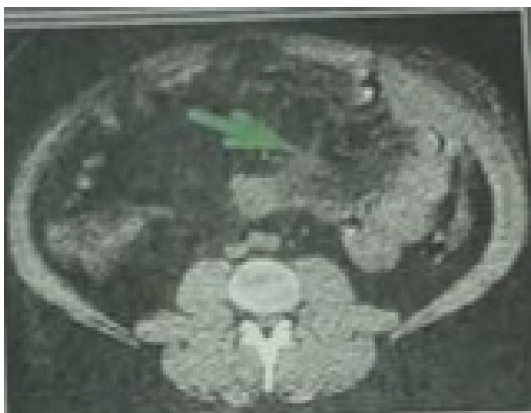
multislice CT scan revealed bowel thickening with mural edema and evident mesenteric congestion
